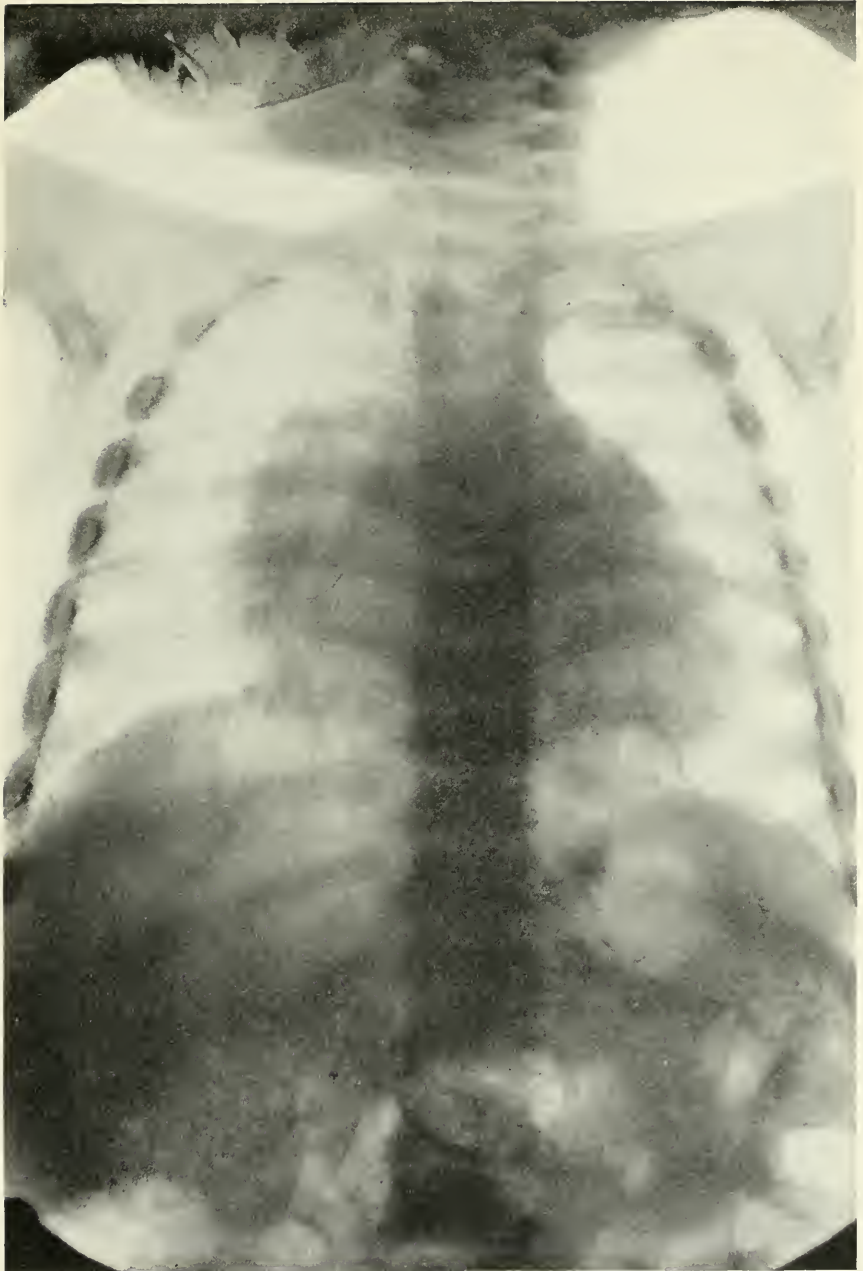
ROENTGENOGRAM OF CHEST OF O. D., THREE DAYS BEFORE DEATH.
